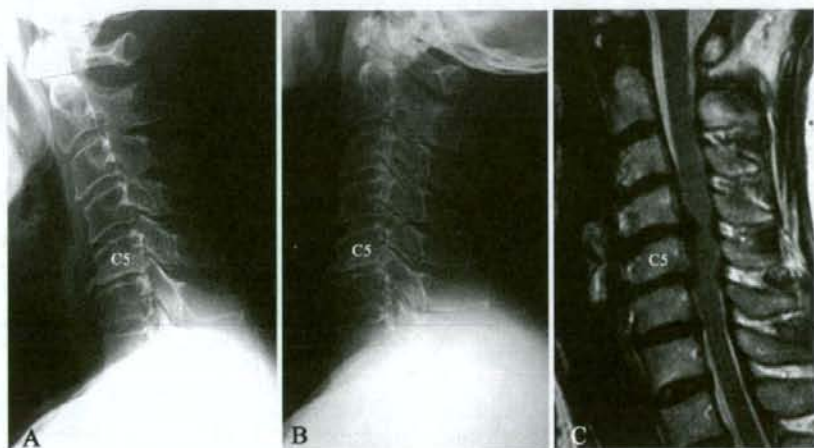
Case 2. Flexion (A) and extension (B) cervical radiographs obtained at the initial visit in a patient with segmental-type OPLL. The residual space available for the cord is 9 mm at the C-5 level, and the C1-7 ROM is 52°. A T2-weighted midsagittal MR image obtained at presentation (C) indicates that impingement of the spinal cord at the C4-5 level is seen, but no HSCs are visible.
